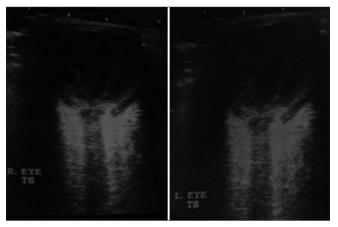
Ocular ultrasound scan
